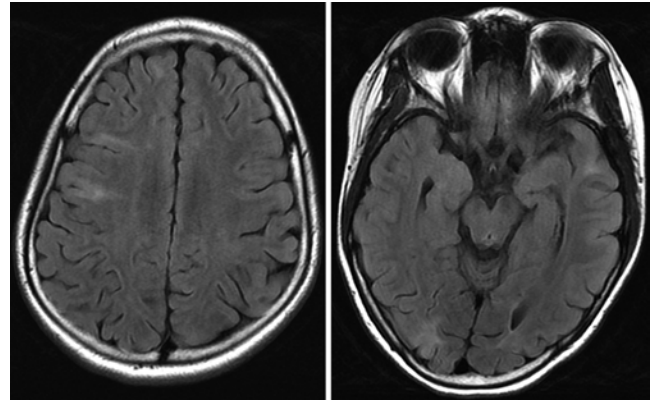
Axial MRI/FLAIR sequences demonstrating multiple cortical tubers, as well as the right occipital tuber that was ultimately resected following evaluation.
